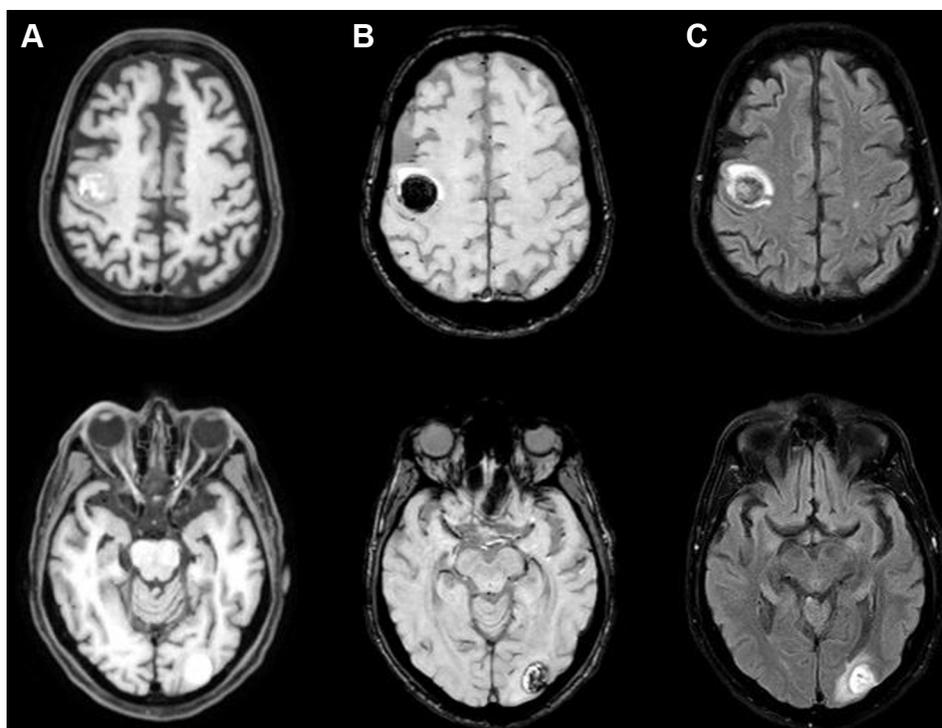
(A) Bilateral mass lesions within the (top) right frontal lobe (18 mm × 18 mm) and (bottom) left parietal occipital region (17 mm × 15 mm) on T1-weighted magnetic resonance images. Both lesions demonstrate evidence of (B) hemosiderin on susceptibility-weighted pulse sequences and (C) edema on fluid-attenuated inversion recovery (FLAIR) pulse sequence.
